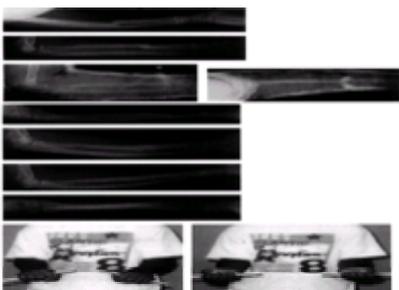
Forearm with subsequent malunion fracture in a 10-year-old boy. A: Radiographs demonstrate displaced fracture of the radius with greenstick fracture of the ulna. B: Acceptable reduction is achieved with completion of the ulnar fracture. The cast is poorly molded along the ulnar border. The patient did not return for follow-up as instructed. C and D: Anteroposterior and lateral radiographs demonstrate midshaft malunion. E: Radiographs and clinical photographs 10 months later demonstrate remodeling. F: Range of motion and function are normal. The patient is not aware of any cosmetic deformity.
